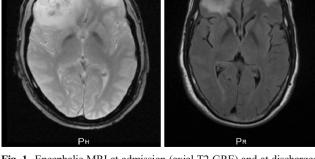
Encephalic MRI at admission (axial T2 GRE) and at discharged (2 weeks lateral axial T2 flair)
